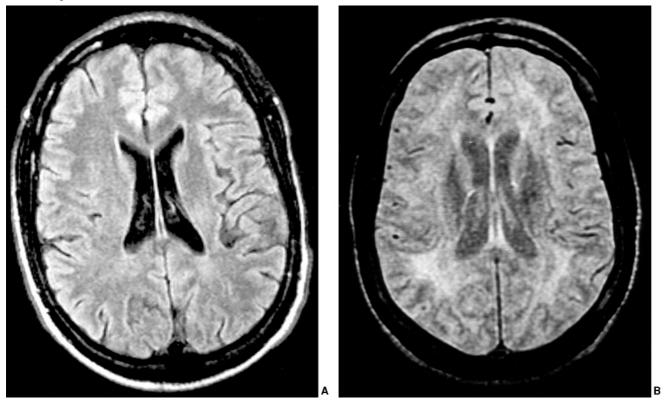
ADC: Brain MRI, T1-weighted with gadolinium, showing increased white matter signal in the periventricular region with no enhancement.
